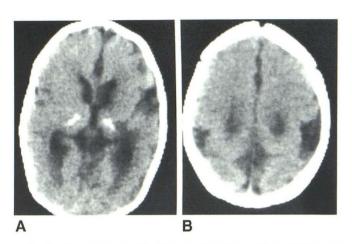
Case 4 (case 7 in [1]). Type I lissencephaly in ILS. A, CT scan at 1 month. B, Higher cut. Areas of pachygyria (e.g., right frontal convexity) and agria (medial frontal lobes, insulas, probably parietal lobes) with unusual posterior displacement of sylvian region. Bilateral thalamic calcifications have not been observed in patients with MDS. (A reprinted from [1].)
